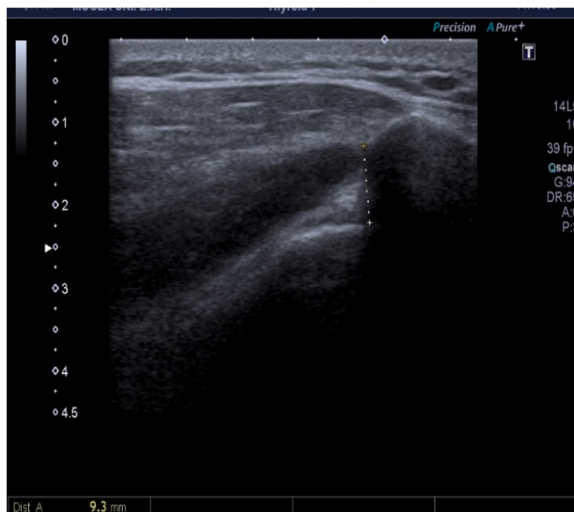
Calculation of acromiohumeral distance on ultrasound image.
